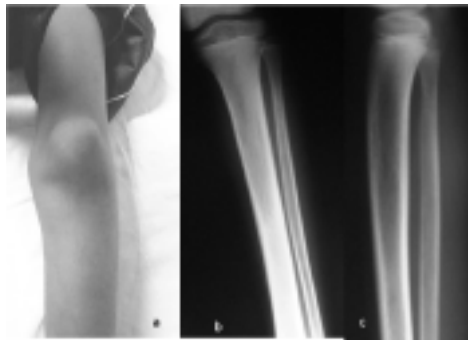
Clinical Photograph of the patients with Radiographs at the time of presentation. 1a) ?, b) ?, c)?
